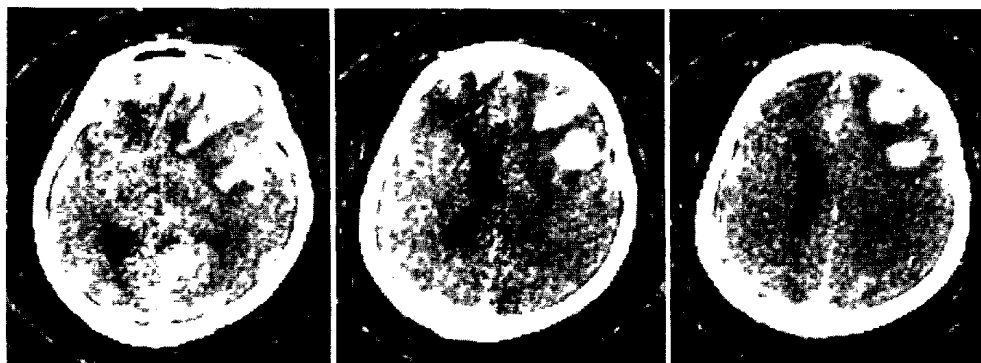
Intracerebral hematomas. 59-year-old male. CT was performed 3 days after trauma. Two large hematomas with wedge-shaped appearance can be seen in the right frontal area. Some small hemorrhages can also be recognized in the left frontal area.
